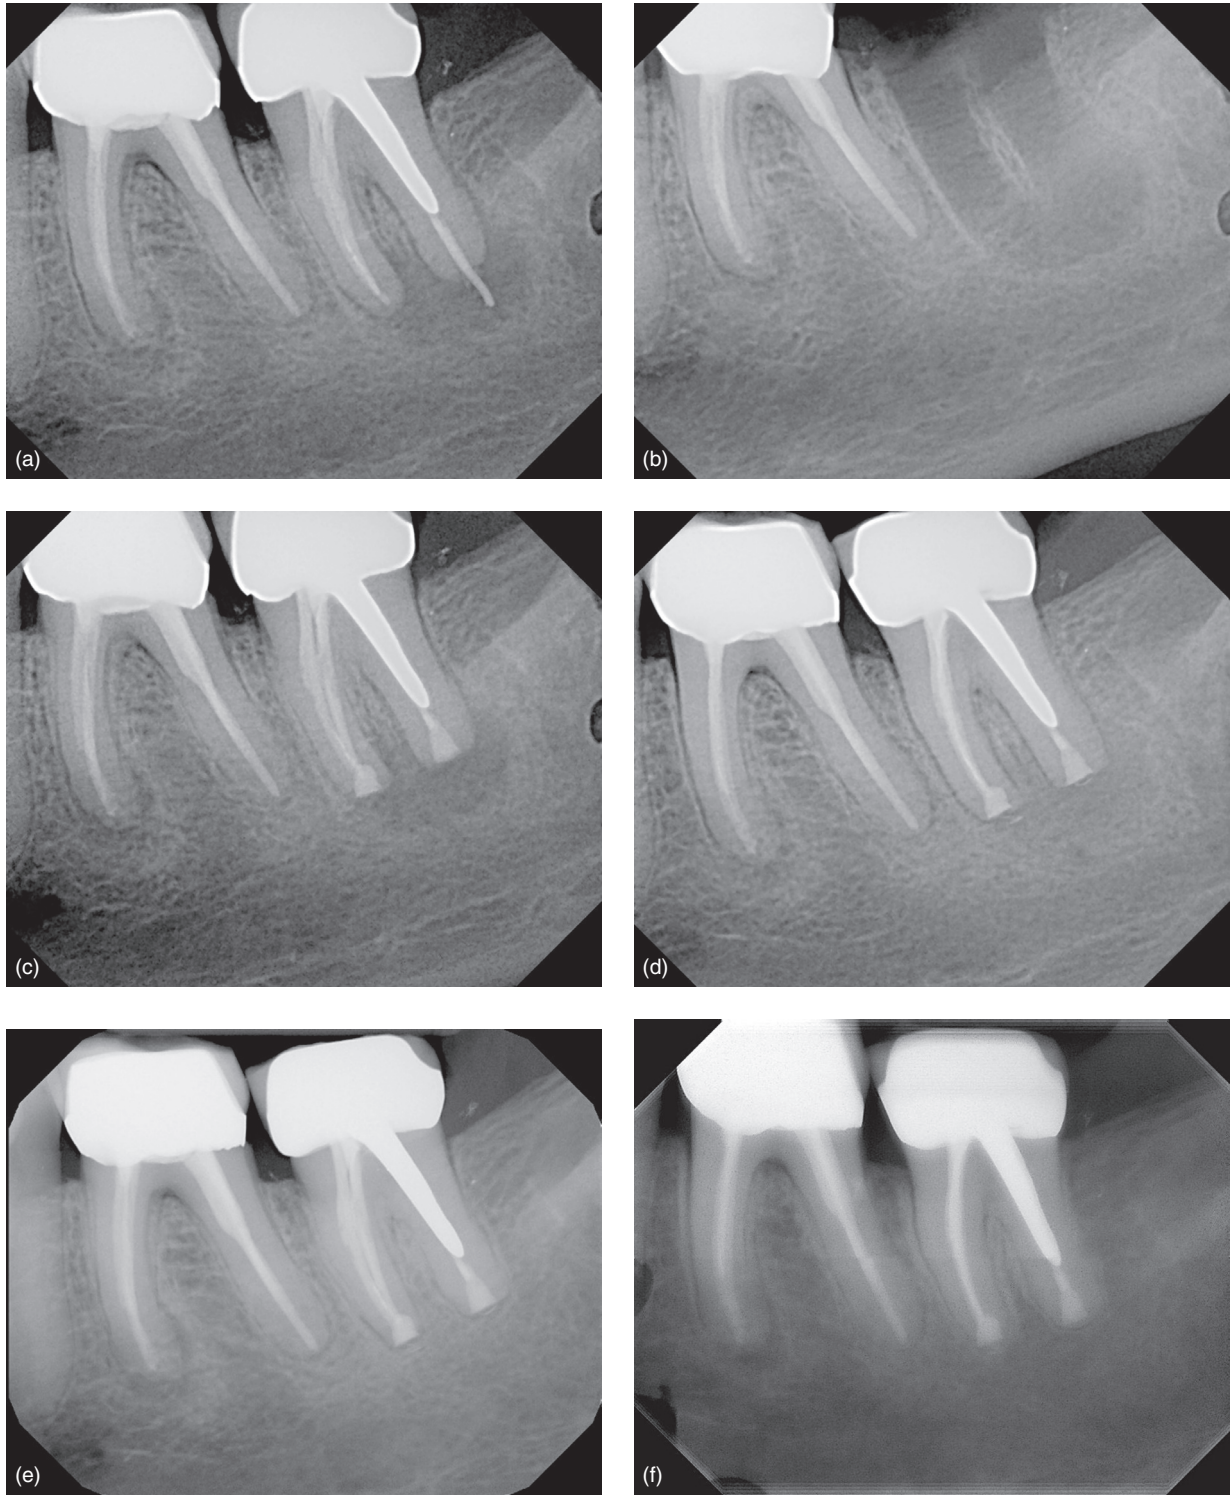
Mandibular left second molar was referred on a Friday afternoon as an emergency with the patient in severe pain and already on antibiotics, NSAIDs, and narcotics for several days without relief. Conservative retreatment with a large cast post/core would be time consuming and most likely cause destruction of the tooth. Even if post removal could be performed, the excess gutta percha would probably snap off the end of the tooth into the lesion. An “emergency” replantation was performed, and the patient was completely asymptomatic within 2 weeks. (a) Preop radiograph; (b) radiograph to show that the excess gutta percha came out with the tooth as well as intact interseptal bone, which will allow excellent stabilization upon replantation; (c) postop radiograph; (d) 5 week follow-up radiograph; (e) 1 year follow-up with complete healing; (f) 2 year follow-up (Courtesy of Dr Kenneth Lee.)
